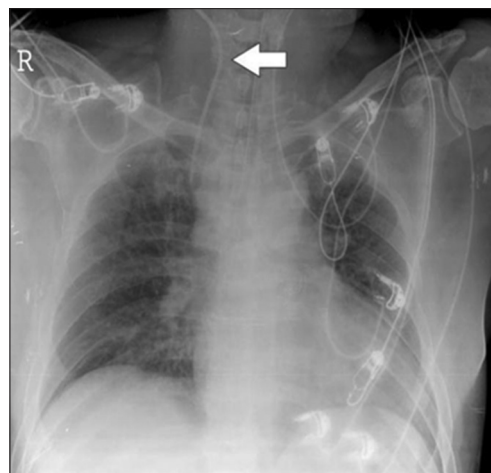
Catheter misplacement to the vertebral vein.^[37] Chest X-ray shows that the central venous catheter passes the transverse processes of the 6th and the 7th cervical vertebrae (arrow).
